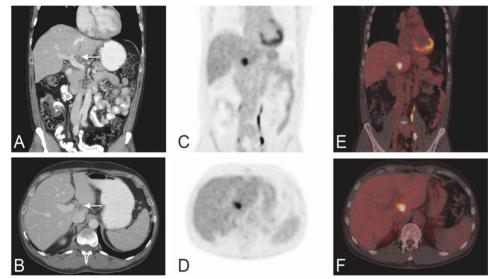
Solitary liver metastasis. Coronal (A, C, E) and axial (B, D, F) images of a solitary liver metastasis in the caudate liver lobe (segment I). Representative images of CT (A, B), PET (C, D) and PET/CT (E, F).
